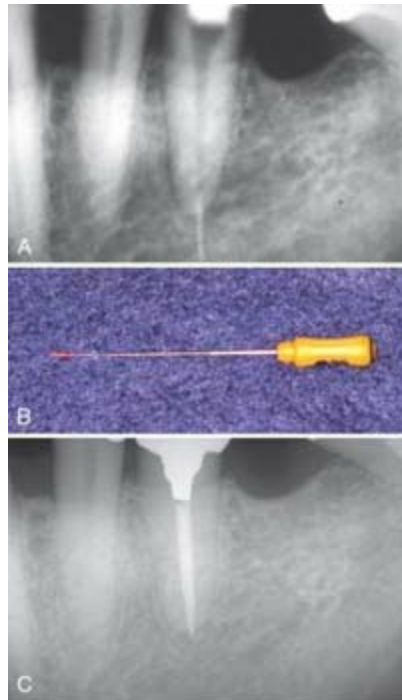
Removal of overextended gutta-percha. A, Preoperative radiograph showing overextended filling material. B, A small Hedstrom file pierces the overextended material and retrieves it. C, Eighteen-month reevaluation. The tooth is asymptomatic.
